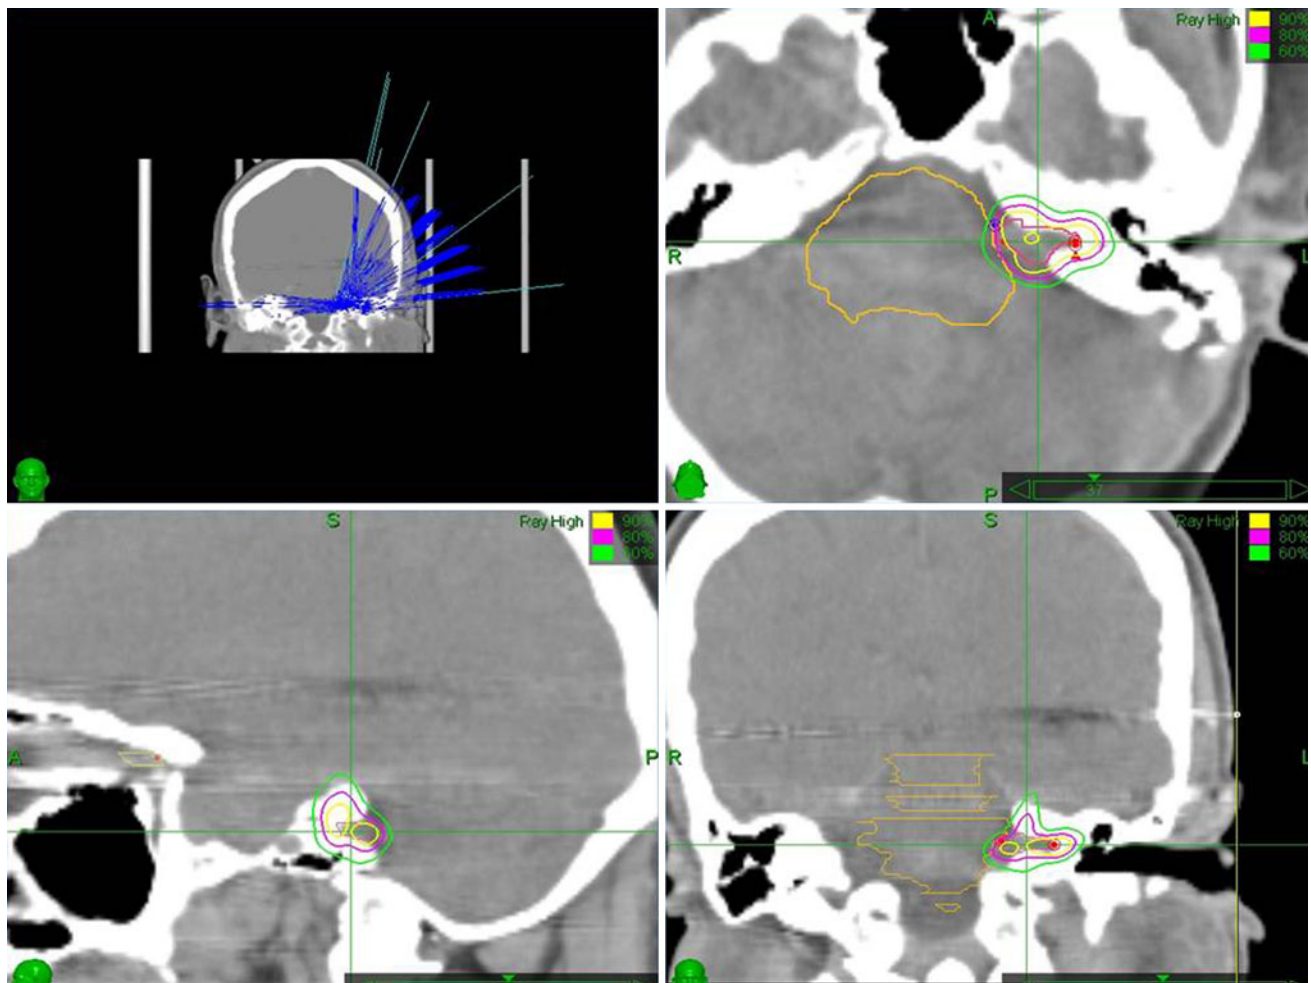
CT scan images showing dose distribution of AN patient planned Robotic radiosurgery (CyberKnife) system
